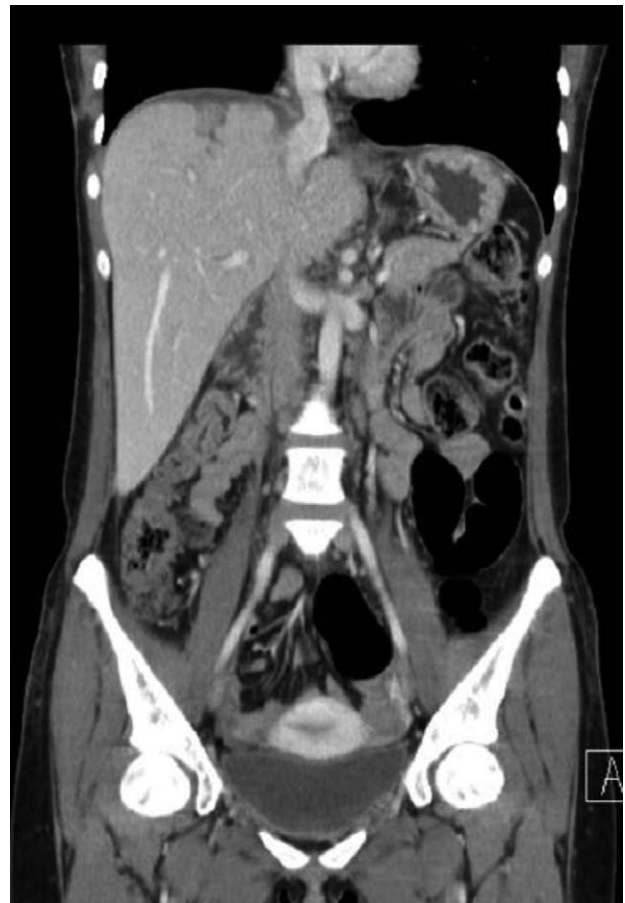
A coronal view of a follow-up abdominal CT scan on postinjury day 59 demonstrates no more ascites, and the lumen of suprahepatic IVC grew larger compared to the previous CT.
